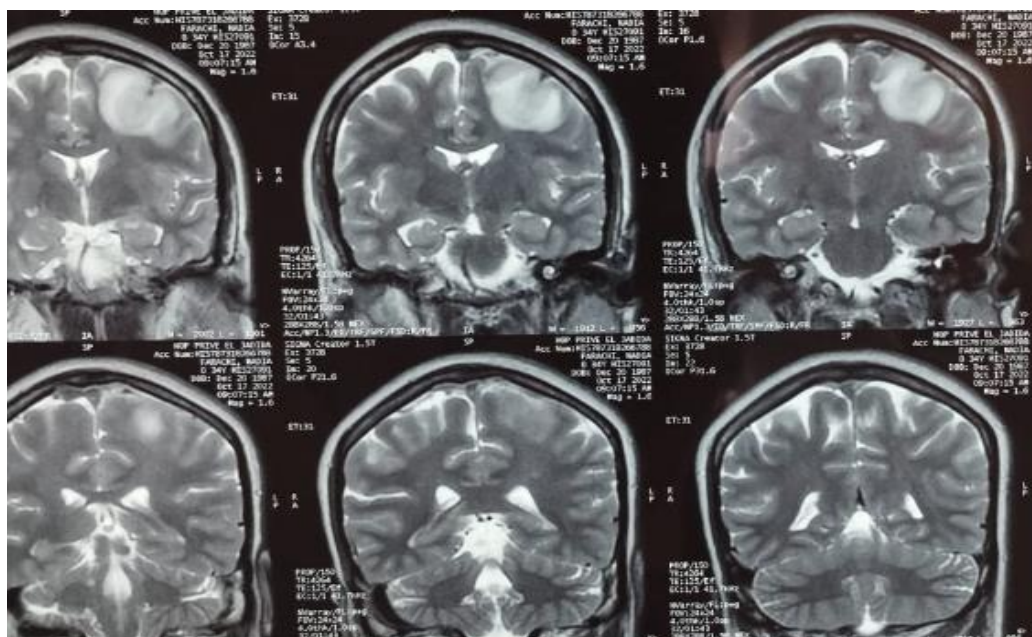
Angio-MRI of the patient: cortical cerebral venous thrombosis and superior longitudinal sinus thrombosis complicated by parietal ischemic-hemorrhagic venous infarction
